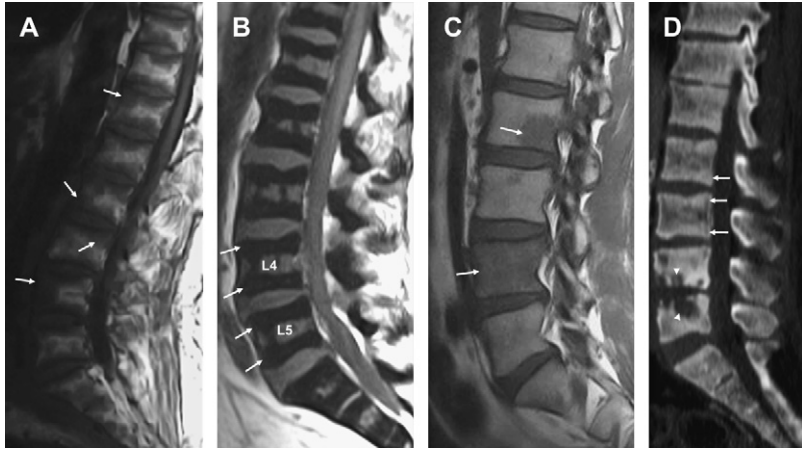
Bone marrow disease. (A) Non-Hodgkin's lymphoma. Sagittal T1—diffuse patchy bone marrow replacement, mainly along the end plates (*arrows*). (B) Osteopetrosis. Sagittal T1—end-plates band-like hypointensity resulting from sclerosis (*arrows*), somewhat mimicking the appearance in (A). Note the uniform pattern indicating benign process. (C) Sarcoidosis. Sagittal T1—patchy to diffuse vertebral marrow replacement (*arrows*) with positive bone scan (not shown); biopsy showed granulomatous changes. (D) CT sagittal reformatted—band-like irregular sclerosis along the end plates (ruger jersey appearance) resulting from renal osteodystrophy (*arrows*). Note superimposed DO with bone erosion (*arrowheads*). Destructive spondyloarthropathy may have similar appearance.
